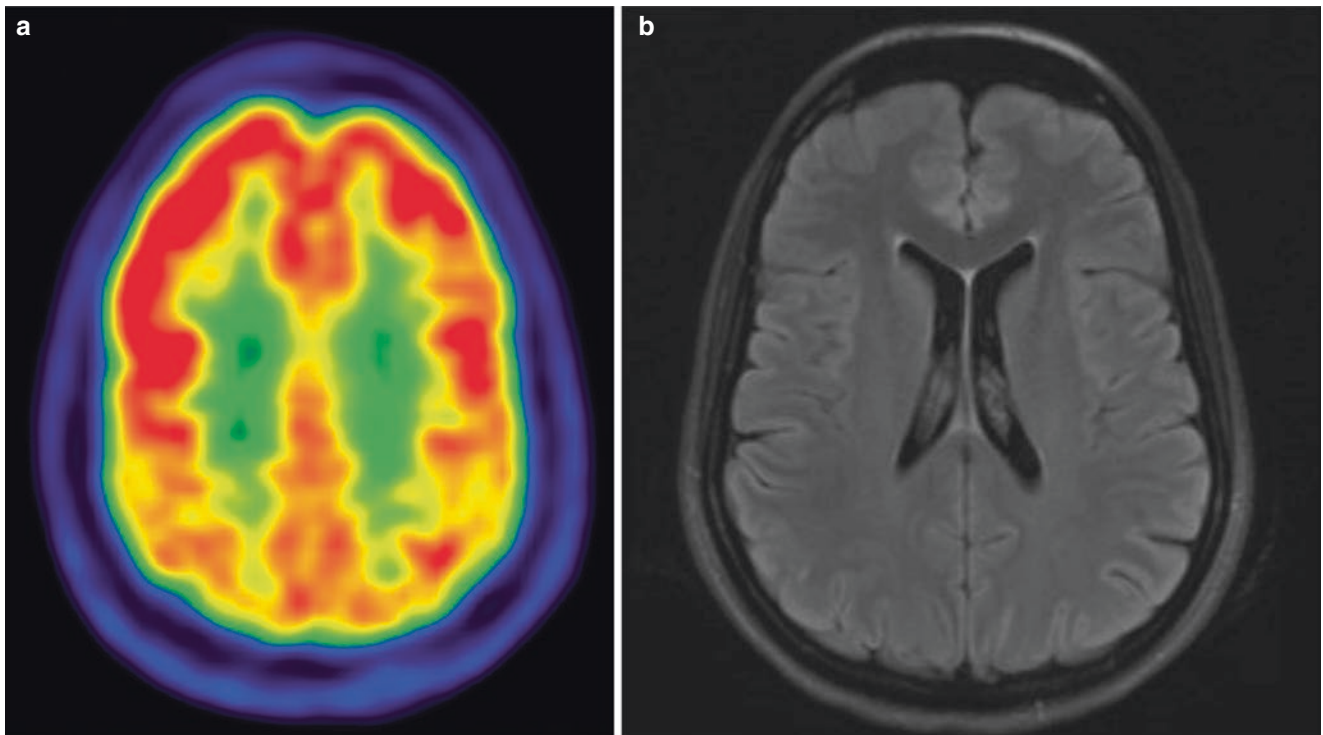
Posterior hypometabolism with normal brain MRI during acute NMDAR encephalitis. (a) Brain positron emission tomography (PET): red and orange indicate areas of highest metabolism, yellow indicates intermediate metabolism, and green and blue correspond with low metabolic activity. Note the relative hypometabolism in the bilateral occipital lobes, especially when compared with the frontal lobes.
